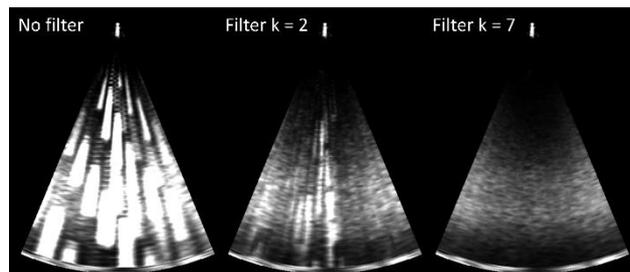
Effect of Calypso signal on ultrasound images (left) and result of an increasing amount of temporal filtering ($k = 2, \dots, 7$).
